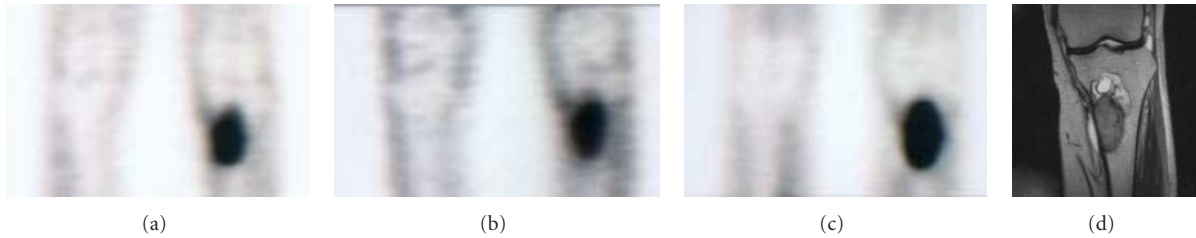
A 43-year-old female with osteosarcoma. ^{18}F -FDG (SUV = 6.0) (a), ^{18}F -FAMT (SUV = 2.0) (b), and ^{11}C -choline (SUV = 9.3) (c) demonstrated high tracer uptake in the tumor of the left tibia, which corresponded to the area that was enhanced on MRI image (d).
